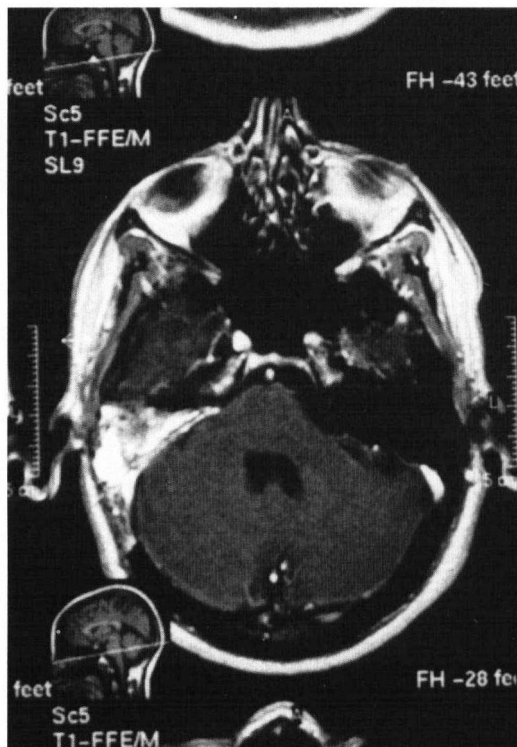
Same patient as in Fig. 1. Magnetic resonance imaging test performed 1 year after the surgery. The fat has shrunk to approximately 50% of the original volume. The brain tissue has reexpanded to its normal position.
